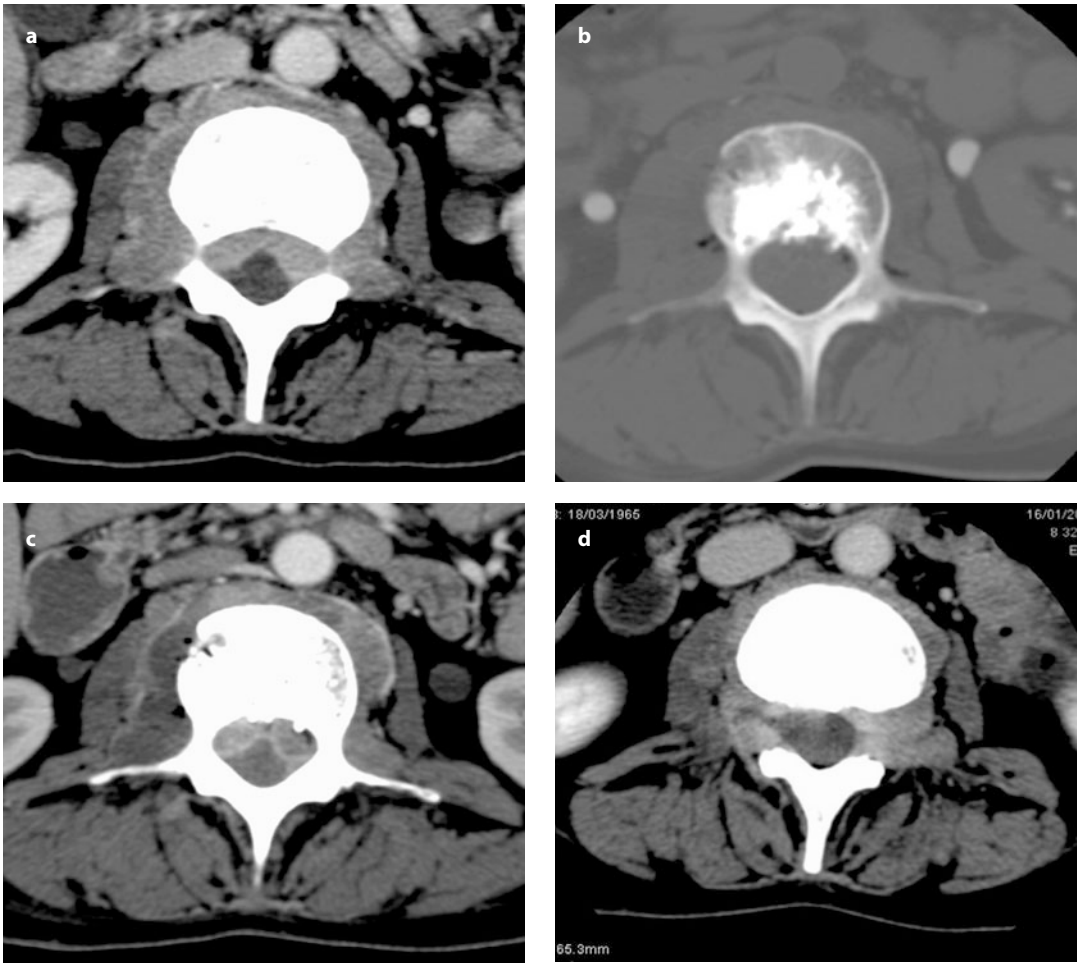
Spontaneous regression of epidural tumor extension in a female with T11 involvement due to breast cancer metastasis and paraparesis. The preoperative contrast-enhanced CT study shows tumor extension into the perivertebral space and spinal canal with spinal-cord compression (a). PMMA augmentation is undertaken involving mainly the posterior-third of the vertebral body of T11 (b). Upon immediate contrast-enhanced follow-up, no enhancement of the epidural intrathecal lesion and paravertebral lesion on the right side can be seen, which is probably related to ischemic changes induced by PMMA augmentation (c). At 4-week follow-up, the paraparesis has resolved and no recurrence of the tumor can be seen in the spinal canal (d)
